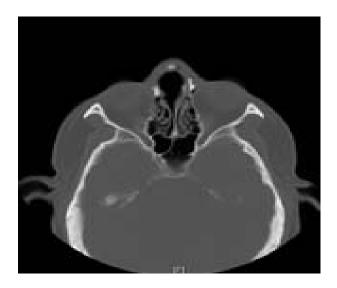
CT scan axial view paranasal sinus post-operative showing complete removal of the mucocele.
